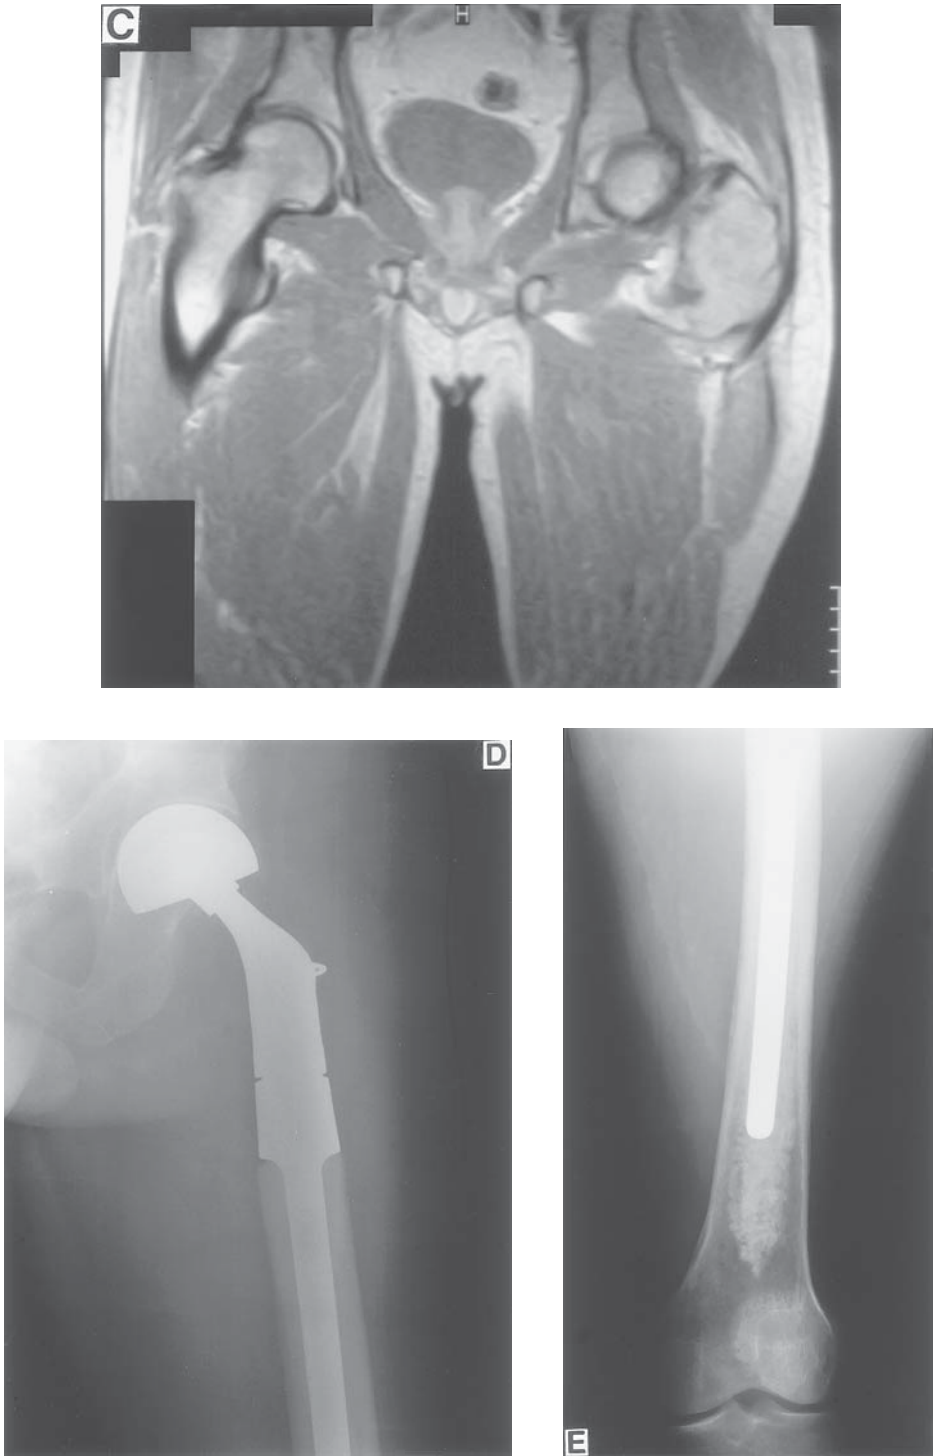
(Continued). (C) MRI showing large soft tissue replacement mass. (D) and (E) Proximal femoral bipolar replacement with gluteus medius attachment through radiolucent broad synthetic suture to the component.
